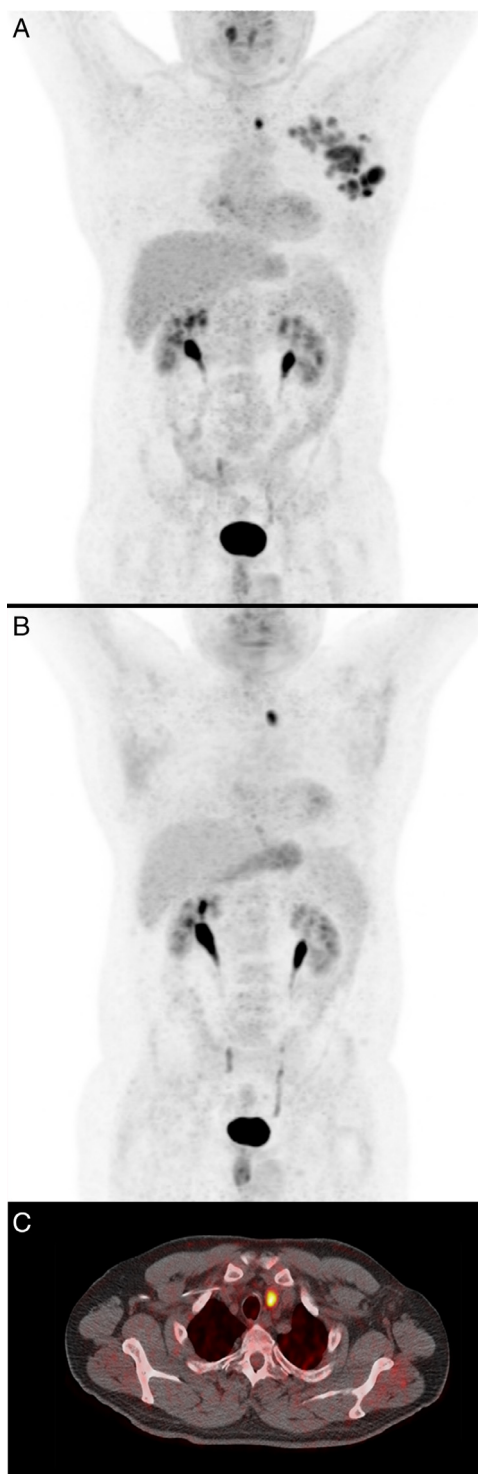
(A) Staging ^{18}F -FDG PET/CT (Maximum Intensity Projection, MIP image) shows pathological uptake in the left paratracheal site, in the ipsilateral axillary and intrapectoral lymph nodes. (B, C) Interim ^{18}F -FDG PET/CT (coronal MIP image and axial slice of fusion PET/CT) shows no radiopharmaceutical uptake in the left axillary and intrapectoral lymph nodes but a focal area of pathological uptake in the left paratracheal site persisted (SUV max 10.5).
